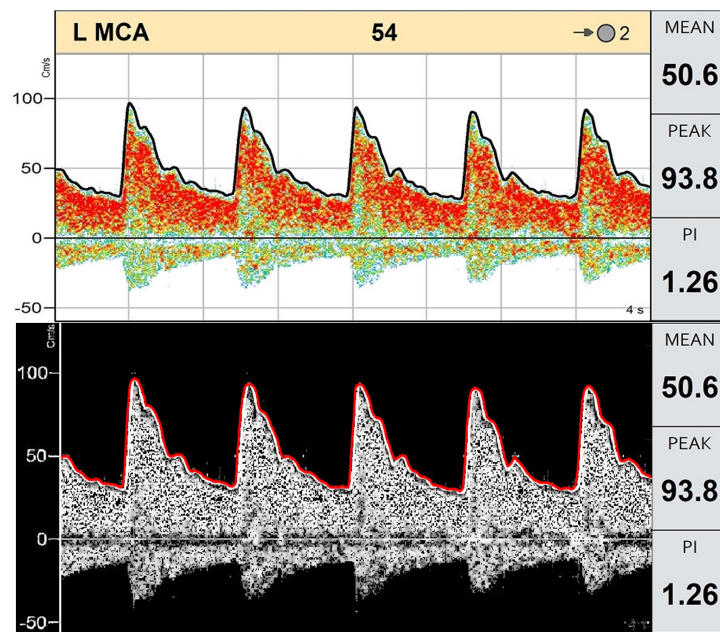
Transcranial Doppler ultrasound measurement of velocities in the left middle cerebral artery (top) converted to a tile with higher contrast between the measurement and the background used by the automated tracing algorithm (bottom)
